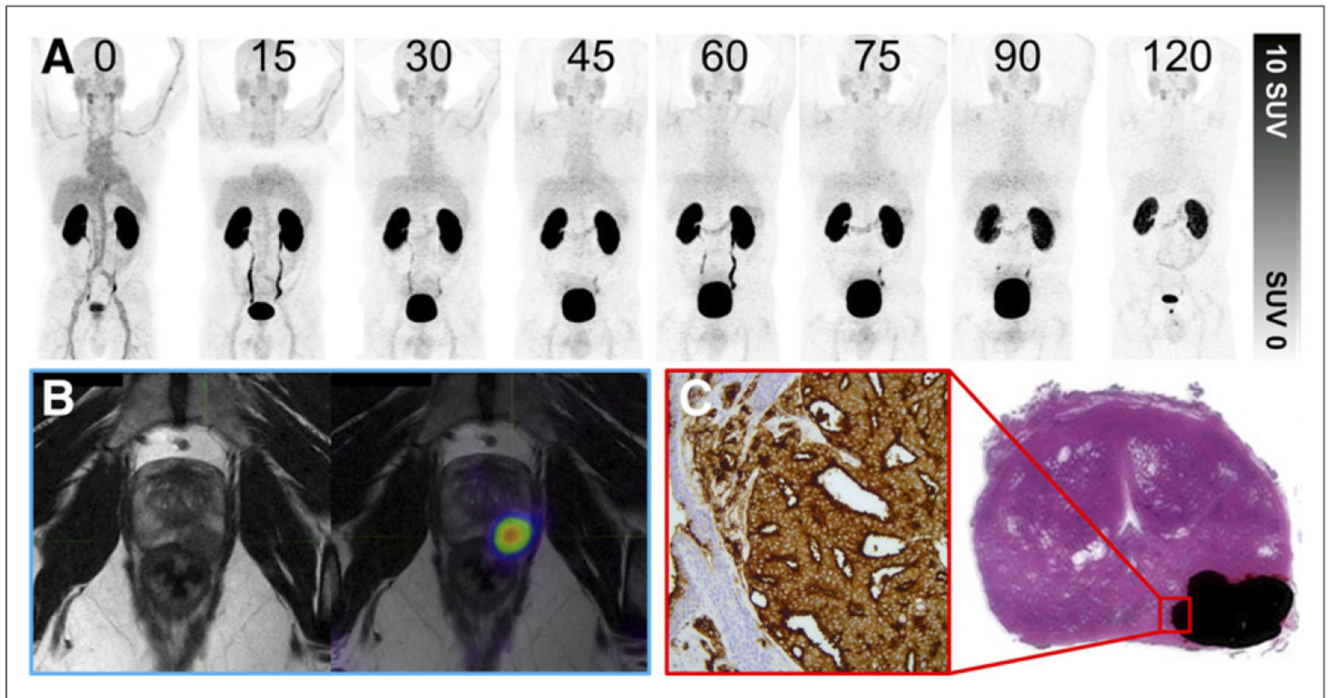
Patient with prostate adenocarcinoma with Gleason score of 4 + 4 = 8 and PIRADS 5 on prior multiparametric MRI.
